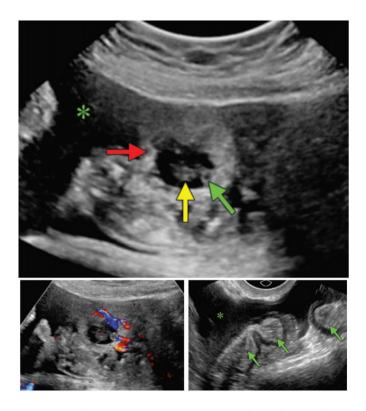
Abdominal ectopic pregnancy. (a) Sagittal transabdominal grayscale US image shows a fetal pole (yellow arrow) and yolk sac (green arrow) in an intra-abdominal gestational sac. Note the peripheral echogenic margins (red arrow) around the gestational sac. Hemoperitoneum (\*) is also seen. (b) Sagittal transabdominal color Doppler US image shows peritrophoblastic flow flowing around the gestational sac. (c) Sagittal transvaginal grayscale US image shows intestinal loops (green arrows) and hemoperitoneum (\*) around the abdominal gestational sac <sup>5</sup>
